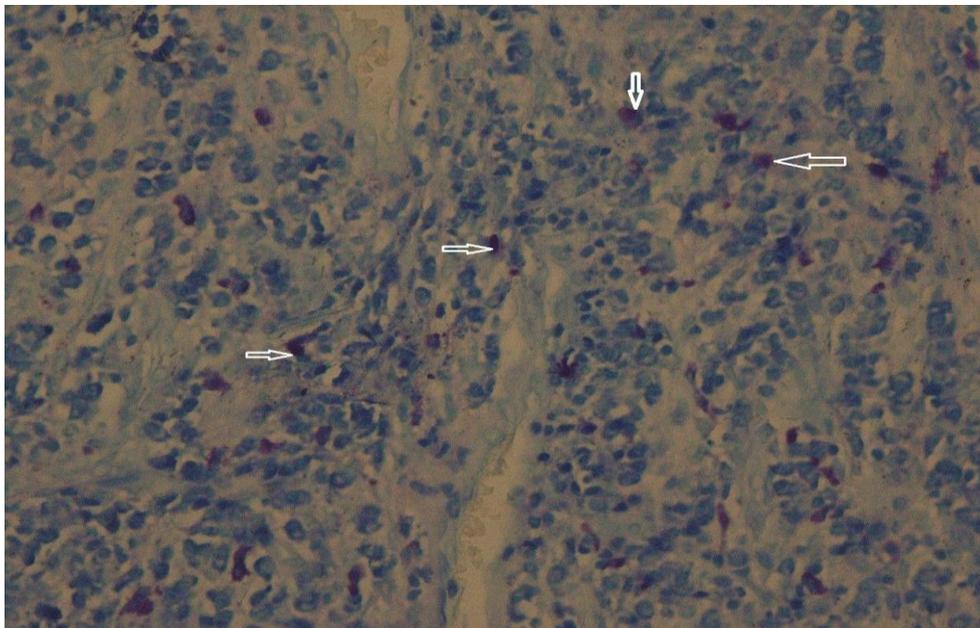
Mast cells(arrows)in a case of periapical granuloma.(Toluidineblue, * 100)
